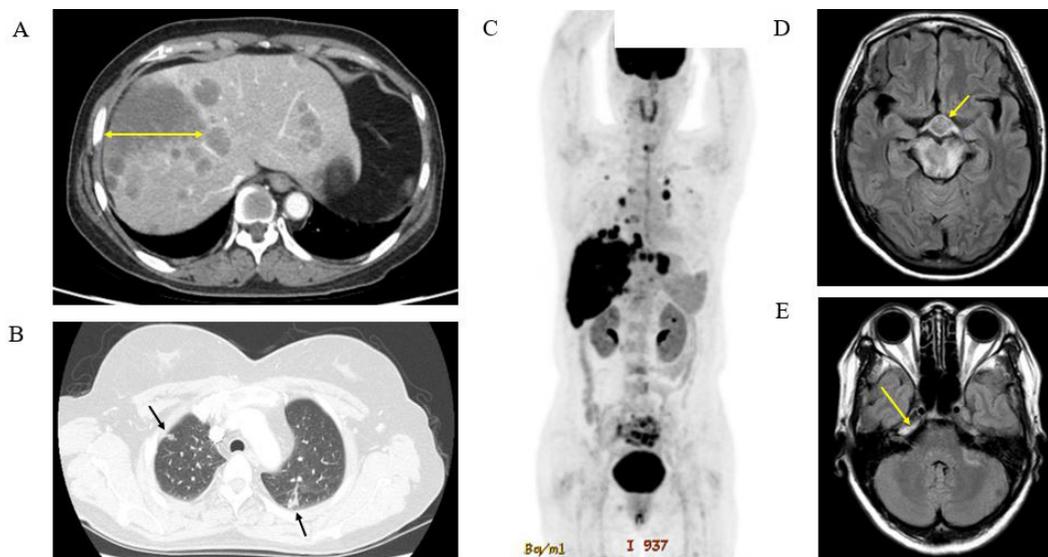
(A) Liver mass of 11 cm (long axis) in abdominal-pelvis computerized tomography (CT), (B) Chest CT showing multiple lung metastasis, (C) Positron emission tomography showing lung, liver, lung metastasis, (D) Brain magnetic resonance imaging (MRI) showing 1.7 cm mass on the pituitary, (E) Brain MRI showing right acoustic metastasis (yellow arrow)
